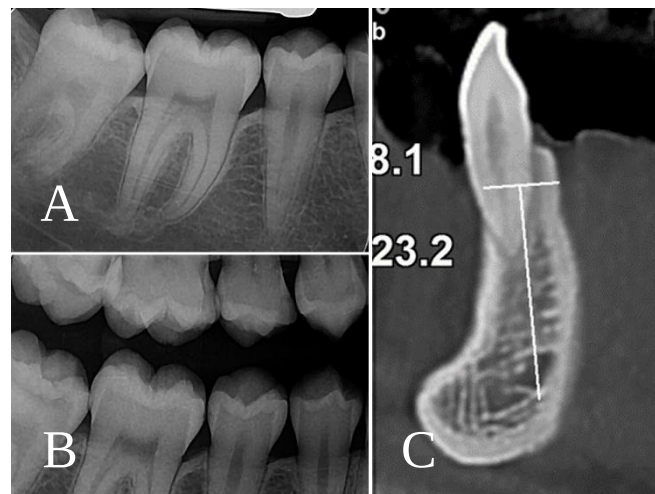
Radiographic assessment can provide detailed views of the root, which enable indirect identification of the CEJ. (A) Periapical radiography. (B) Bitewing radiography. (C) A cross-sectional view of Cone-beam computed tomography.
